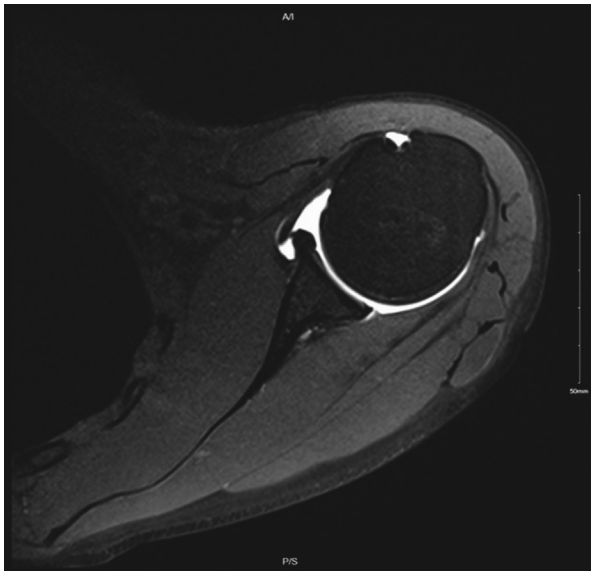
Repeat MRI left shoulder axial view T2 series demonstrating resolution of bony edema after completion of arthroscopic débridement and antibiotic management. MRI, magnetic resonance imaging.
